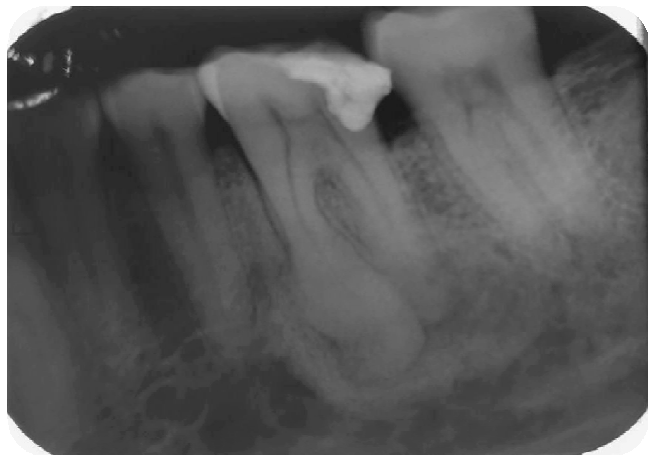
Pre-operative IOPA radiograph
